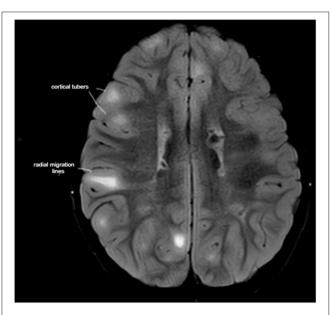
Axial T2-weighted fluid-attenuated inversion recovery (T2-FLAIR) MRI demonstrating high tuber load and radial migration (RM) white lines in a 7-year-old boy with tuber sclerosis complex, normal intelligence, peer relationship problems, and hyperactive/inattention, which correlated negatively with RM lines in the parietal area.
